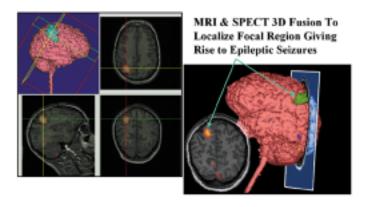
Subtraction interictal SPECT co-registered to MRI (SISCOM) procedure developed using Analyze at Mayo Clinic for precise localization of brain region to be resected in order to alleviate debilitating seizures in epilepsy patients. 3-D SPECT images recorded during and after seizures are registered and subtracted, the difference images are then registered and fused with a 3-D MRI volume image, and the result is volume rendered to localize the seizure focal region.
